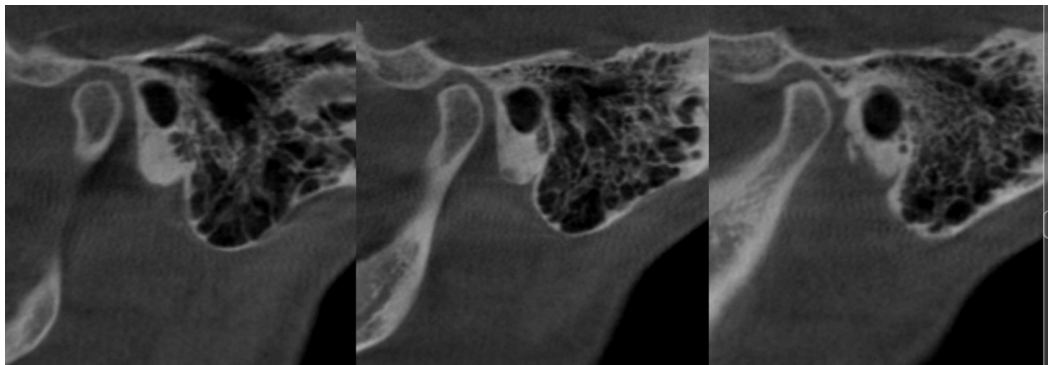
CBCT Corrected Sagittal views of the left TMJ shows Flattening and Sclerosis.
